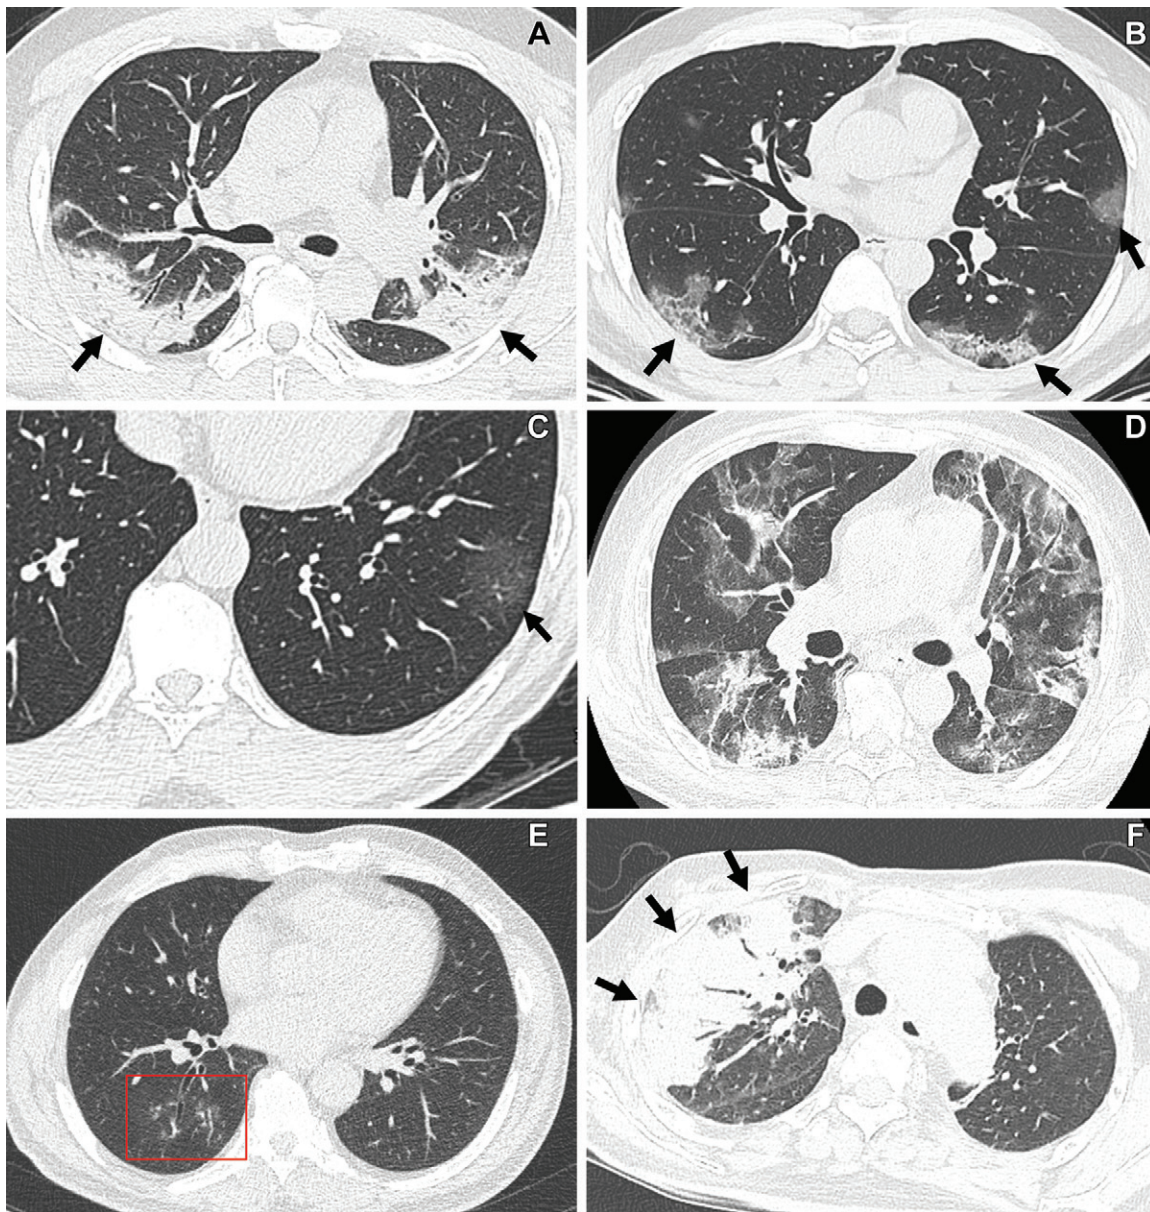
CT findings of COVID-19 pneumonia according to RSNA CT classification schemes. (A, B) “Typical” COVID-19 pneumonia according to the RSNA chest CT classification system. (A) Transverse nonenhanced CT scan (lung window) obtained in a 48-year-old unvaccinated man with a history of hypertension and diabetes seen at the wild type–dominant period shows bilateral areas of consolidation with peripheral distribution (arrows). (B) Transverse nonenhanced CT scan (lung window) obtained in a 40-year-old unvaccinated man with no underlying disease seen at the wild type–dominant period shows patchy areas of mixed ground-glass opacity (GGO) and consolidation with subpleural distribution (arrows). (C, D) “Indeterminate” COVID-19 pneumonia according to the RSNA chest CT classification system. (C) Transverse nonenhanced CT scan (lung window) obtained in a 61-year-old unvaccinated woman with no underlying disease seen at the wild type–dominant period shows focal area of GGO (arrow) in left lower lobe. (D) Transverse nonenhanced CT scan (lung window) obtained in a 65-year-old fully vaccinated man with hypertension, diabetes, and a history of renal transplant seen at the Delta variant–dominant period shows extensive areas of mixed GGO and consolidation without zonal predominance. (E, F) “Atypical” COVID-19 pneumonia according to the RSNA chest CT classification system. (E) Transverse nonenhanced CT scan (lung window) obtained in a 42-year-old woman who received a booster dose with no underlying disease seen at Omicron variant–dominant period shows poorly defined small nodules (box) with peribronchial distribution in the right lower lobe. (F) Transverse nonenhanced CT scan (lung window) obtained in a 68-year-old unvaccinated man with history of cerebrovascular accident seen at Omicron variant–dominant period shows segmental area of consolidation (arrows) with air bronchogram in the right upper lobe.
